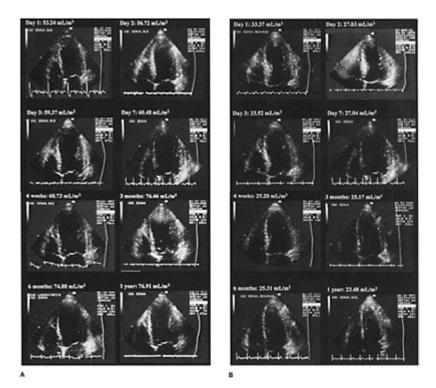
(A) Serial two-dimensional echocardiograms in patient with occluded infarct-related artery and adverse left ventricular remodeling. Note increase in left ventricular end-diastolic volumes over time (from 53.24 ml/m² on day 1 to 76.91 ml/m² after 1 year). (B) In patient with thrombolysis and patent infarct-related artery, left ventricle did not dilate over follow-up (33.37 ml/m² on day 1 and 23.48 ml/m² after 1 year).
